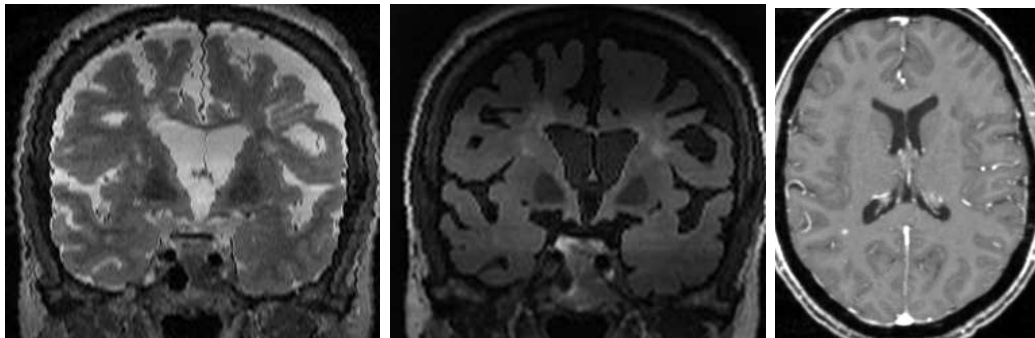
Some artifacts of the workshop database (from left to right): CHB test1 06 T2-w and FLAIR, UNC test1 Case07 T1-w (probably Gadolinium-enhancing T1-w).
